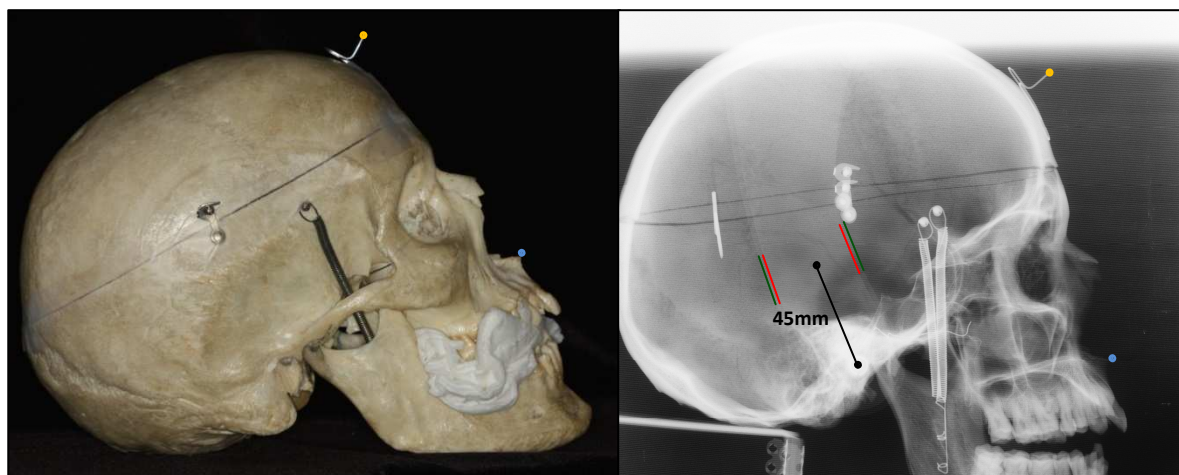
Dry Skull and Radiograph
